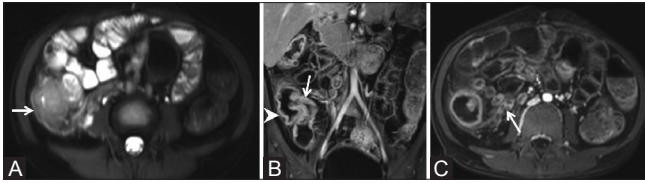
(A-C): Magnetic resonance enterography of intestinal tuberculosis. (A) Axial T2-weighted image showing thickening of ileocecal junction and cecum (arrow). (B) Coronal contrast enhanced T1-weighted image showing thickening and enhancement of ileocecal junction (arrow) with thickened wall of cecum (arrow head). (C) Axial contrast enhanced T1-weighted image showing multiple necrotic mesenteric nodes (arrow)
